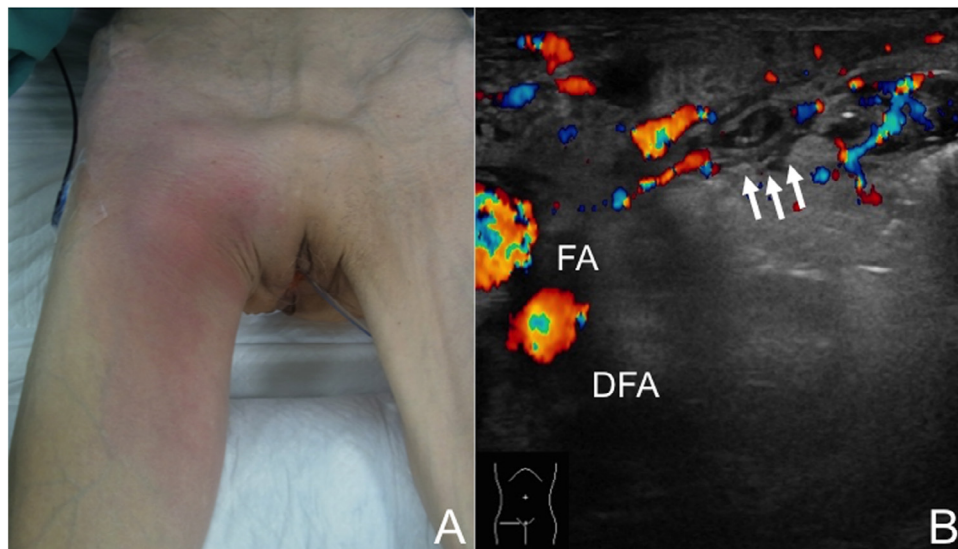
Physical findings and ultrasonographic image.
